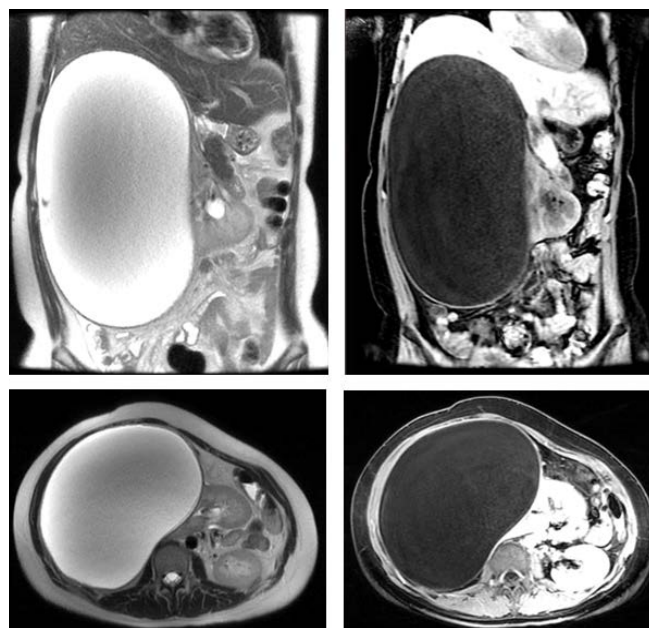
Contrast-enhanced abdominal MRI in coronal and axial planes. A well-defined large cystic lesion located in the upper pole of the right kidney, extending in a craniocaudal direction. The cyst content appears predominantly hyperintense on T2-weighted images and hypointense on T1-weighted images, with heterogeneous areas associated with the presence of floating internal membranes—a characteristic finding of hydatid cysts. No enhancement is observed after contrast administration. Mass effect with compression of surrounding structures is evident.
